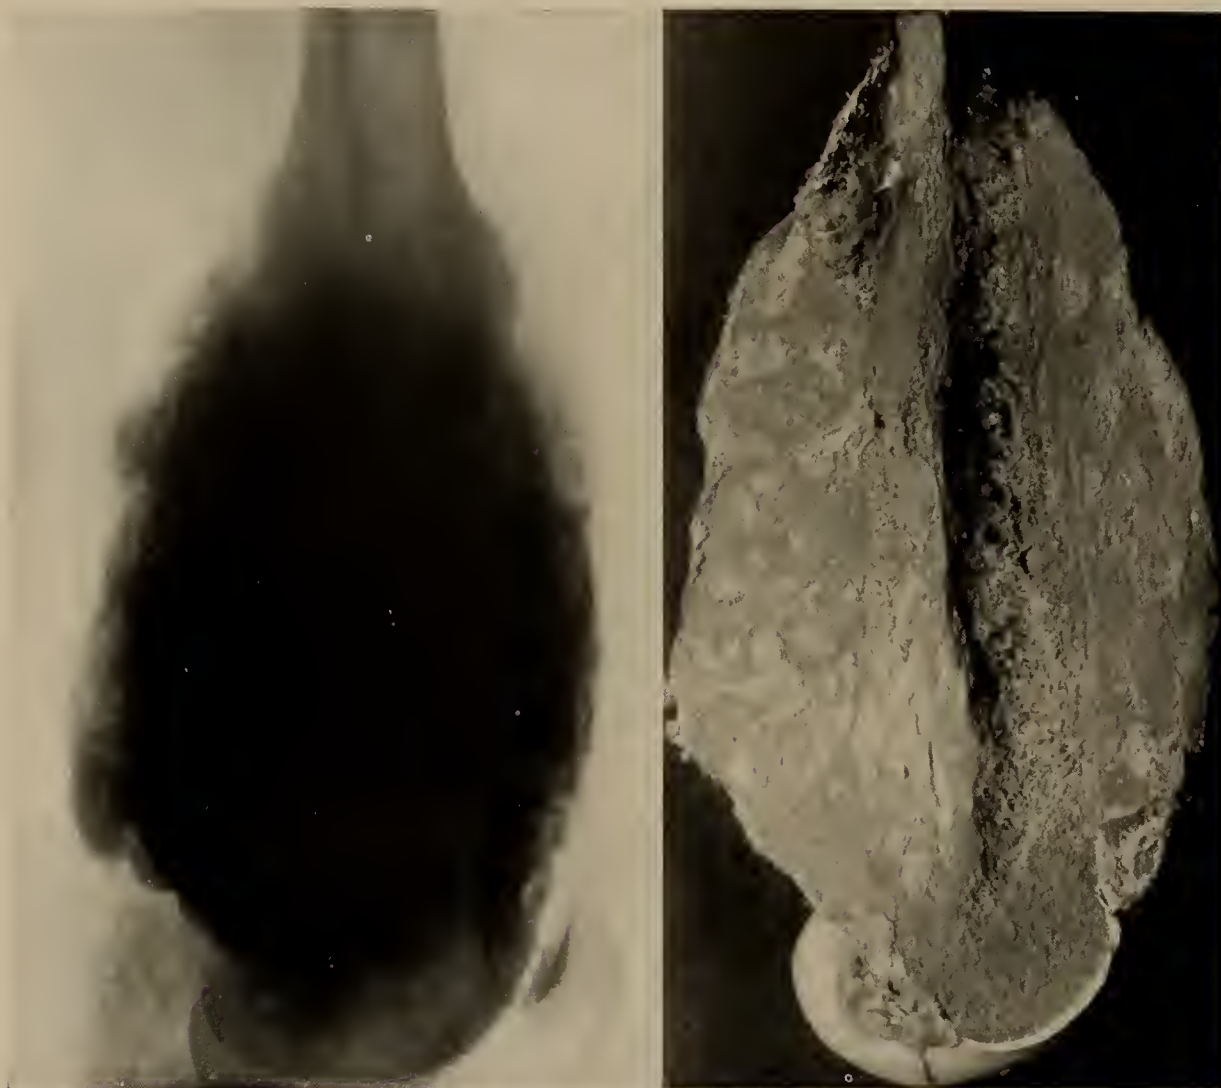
Case 116. See Figure 5. Osteogenic sarcoma in a woman 28 years old. The most outstanding sclerosing tumor in the roentgenogram in the Registry collection. The photograph of the tumor, however, indicates a soft vascular area in the proximal portion of the tumor, and in the medullary cavity. Death with pulmonary metastases 12 years after the onset. Amputation 6 years after the onset and reamputation for local recurrence 3 years later. The roentgenogram was taken 6 years after the onset.
